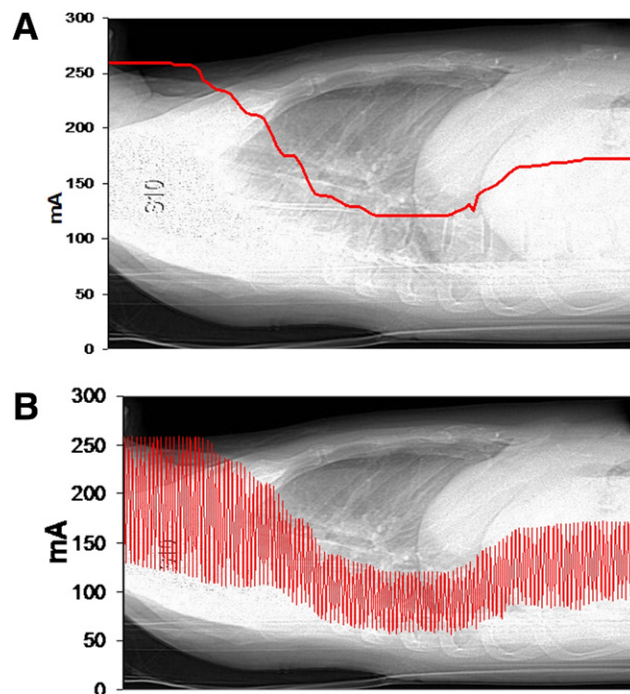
Graphical representation of tube current (mA) modulation in chest CT. Longitudinal modulation of mA is characterized by change in mA at different slice positions on the basis of change in attenuation of the body region along the patient’s length (A). In combined modulation, angular modulation is added to the longitudinal modulation (B) to adapt mA within each slice position on the basis of the cross-sectional asymmetry of body region being scanned.
